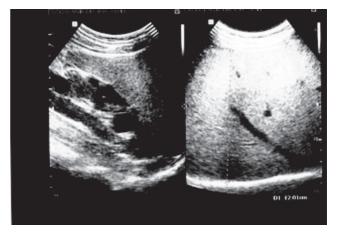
Ultrasound scan showing moderately increased hepatic parenchymal echogenicity with visualization of diaphragm and intrahepatic vessels borders (grade 2 fatty liver).
